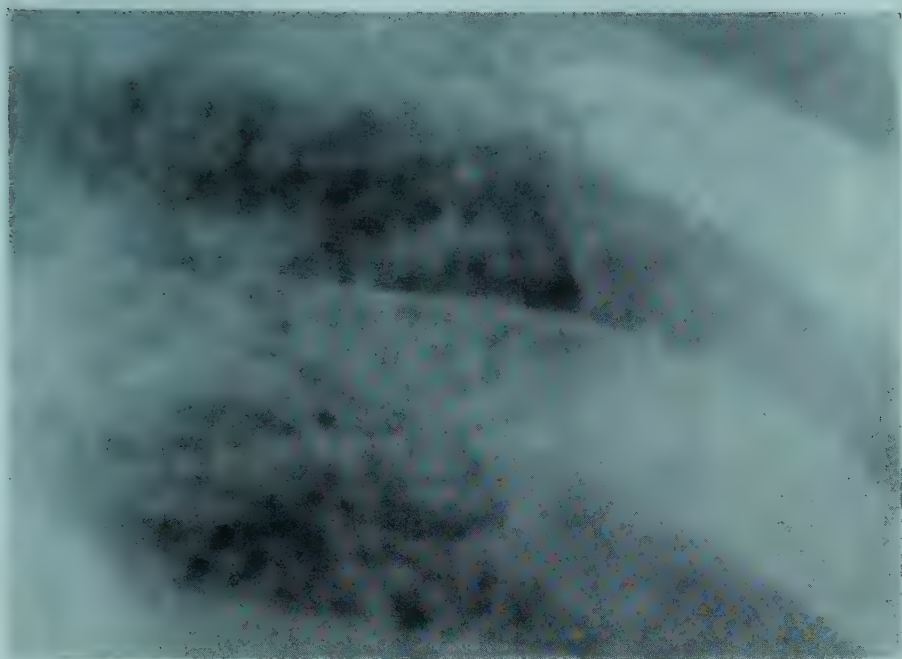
/7. Radiograph of chest during life of a woman with mitral stenosis.  $\times 1\frac{1}{2}$ .
